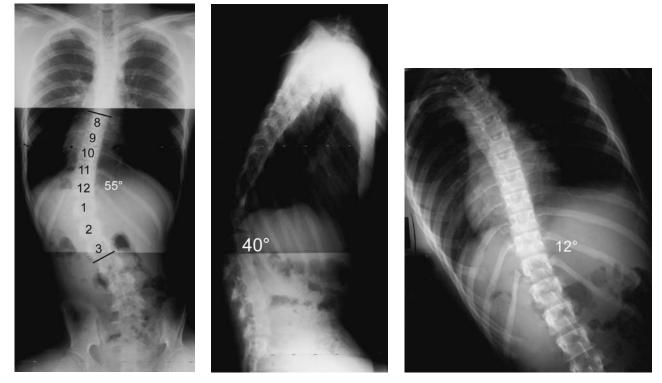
(A,B) This 15-year-old girl has a left paralytic thoracolumbar curve of 55 degrees as a result of spinal cord injury. Her radiographs show a thoracolumbar kyphosis of 40 degrees. (C) The left-bending film shows a flexible curve reducing to 12 degrees.
